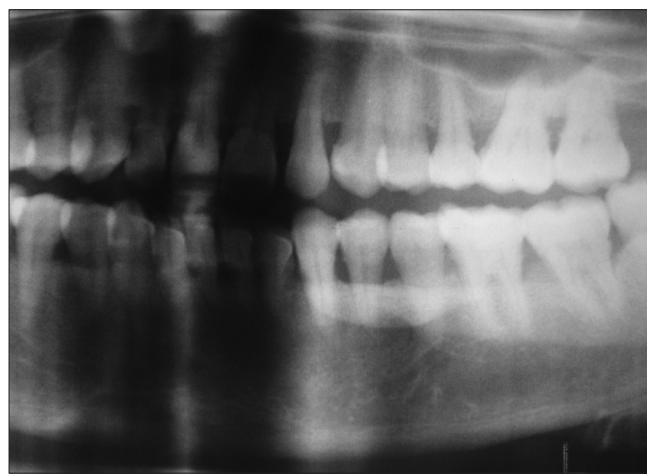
Orthopantomogram of case 2 showing radiopaque calculus on left side
